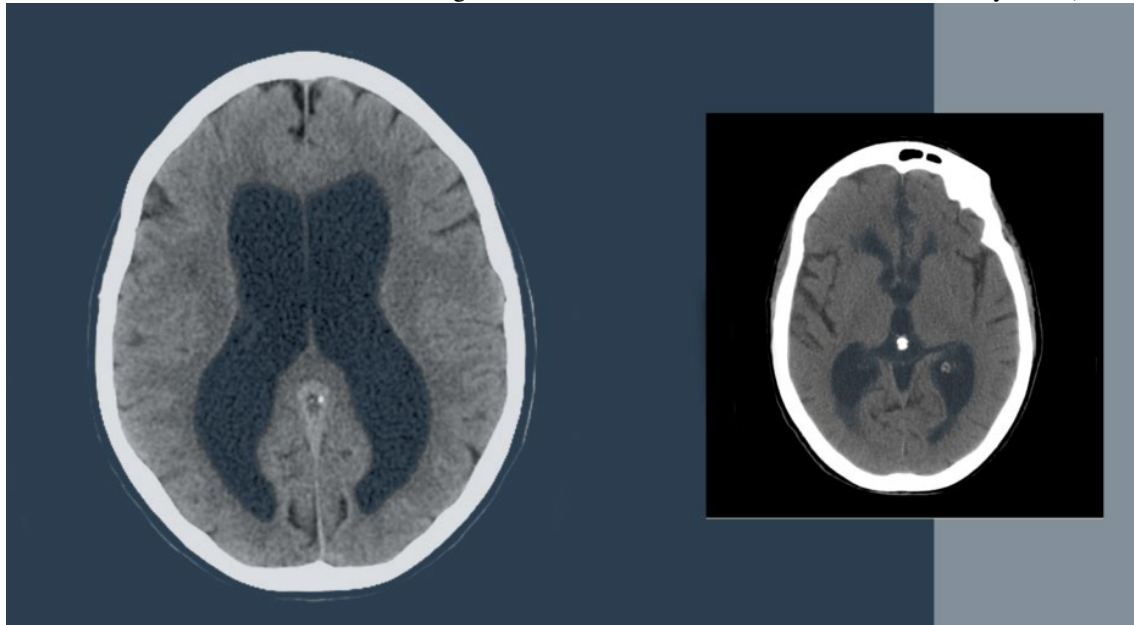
CT scans demonstrate the disorder of hydrocephalus. On the left, a CT scan of a healthy head shows normal ventricle sizes; on the right, a CT of a head with hydrocephalus and noticeably enlarged ventricles. [Source: Advanced Neurosurgery Associates (2024) titled *Types of Hydrocephalus*]. Stress on brain tissue from hydrocephalus can manifest in a diverse set of symptoms that vary by age and encompasses vision disturbances, headaches, nausea, vomiting, balance problems, cognitive changes, and sleep disruptions. One of the most vulnerable areas to be damaged by raised intracranial pressure (ICP) is the optic nerve (II), located behind the eyes. Hydrocephalus often causes impaired vision – another important reason to carry out a fundoscopic examination to check for swelling indicating increased ICP levels. Moreover, hydrocephalus causes ocular issues, with impairment of cranial nerves that control eye movements such as the abducens nerve (VI), trochlear nerve (IV), and oculomotor nerve (III), therefore resulting in conditions like double vision or uncontrolled eye movements. Another cranial nerve that can be affected by hydrocephalus is the trigeminal nerve (V) which provides sensation to the face and controls movements of the jaw. The facial nerve (VII), is another cranial nerve that can also be adversely affected, preventing the ability to make facial expressions and taste food. Often, this leads to sensory loss or paralysis of facial muscles.
